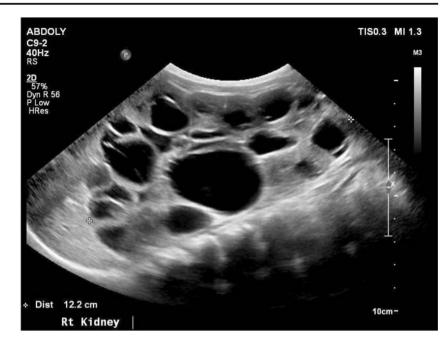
Cystic kidney disease in TSC. Ultrasound of the right kidney in a 1-year-old child with *TSC* and *TSC2/PKD1* contiguous gene deletion syndrome showing massively enlarged kidney containing multiple large cysts
